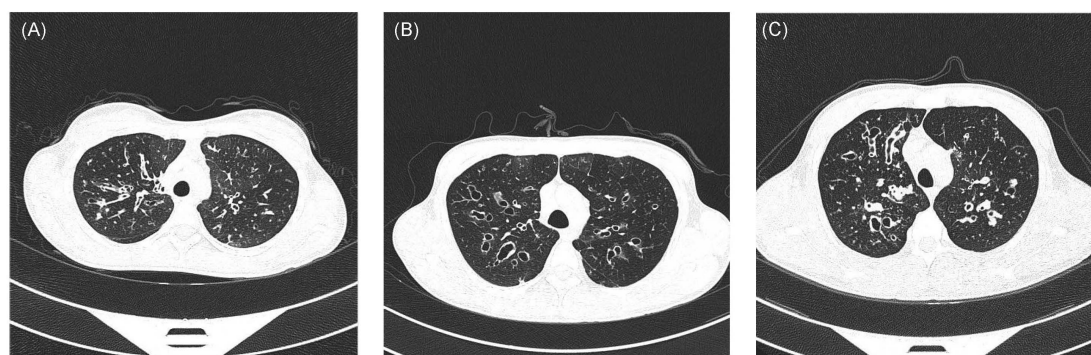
High resolution computed tomography reveals signs of bronchiectasis in all probands [(A), proband I; (B), proband IIa; (C), patient IIb].
